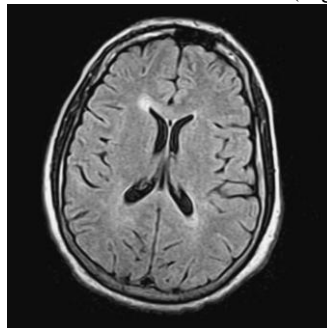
T1-weighted spin echo image of the head.
